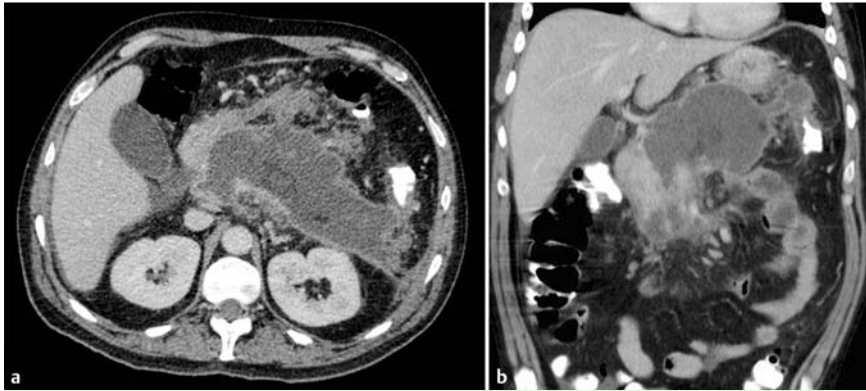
Computed tomographic scans showing walled-off pancreatic necrosis in a 45-year-old patient 4 weeks after acute pancreatitis. a Axial view. b Coronal view.
